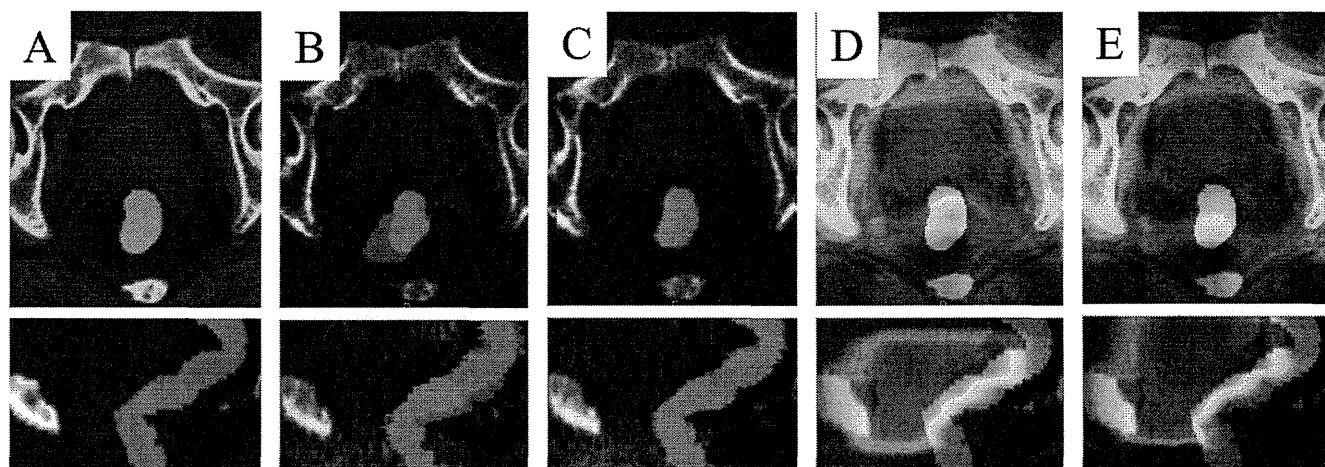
Registration of planning computed tomographic (A) and megavoltage cone-beam computed tomographic images using rigid (B) and deforming (C) methods. (C, D) Dose distribution of the treatment plan is overlapped on the pCT image. Dose distributions were registered using rigid (D) and deforming (E) methods.
